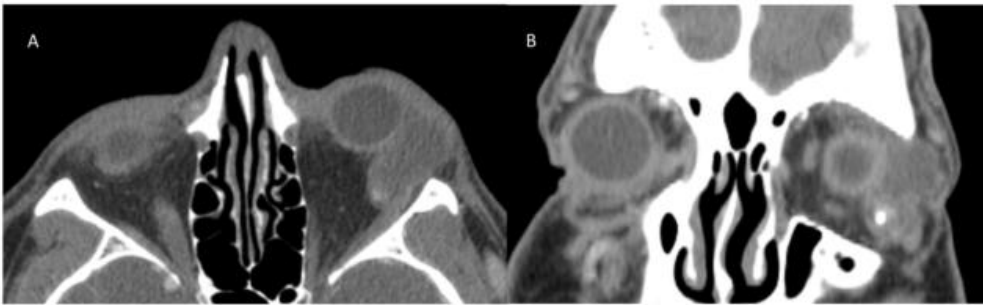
Venous malformation involving the left lacrimal gland and orbit. A and B. Orbital CT shows cystic soft tissue mass involving the left lacrimal gland as well as the extra and intraconal compartment of the left orbit. It has few punctate calcifications, consistent with phleboliths.
